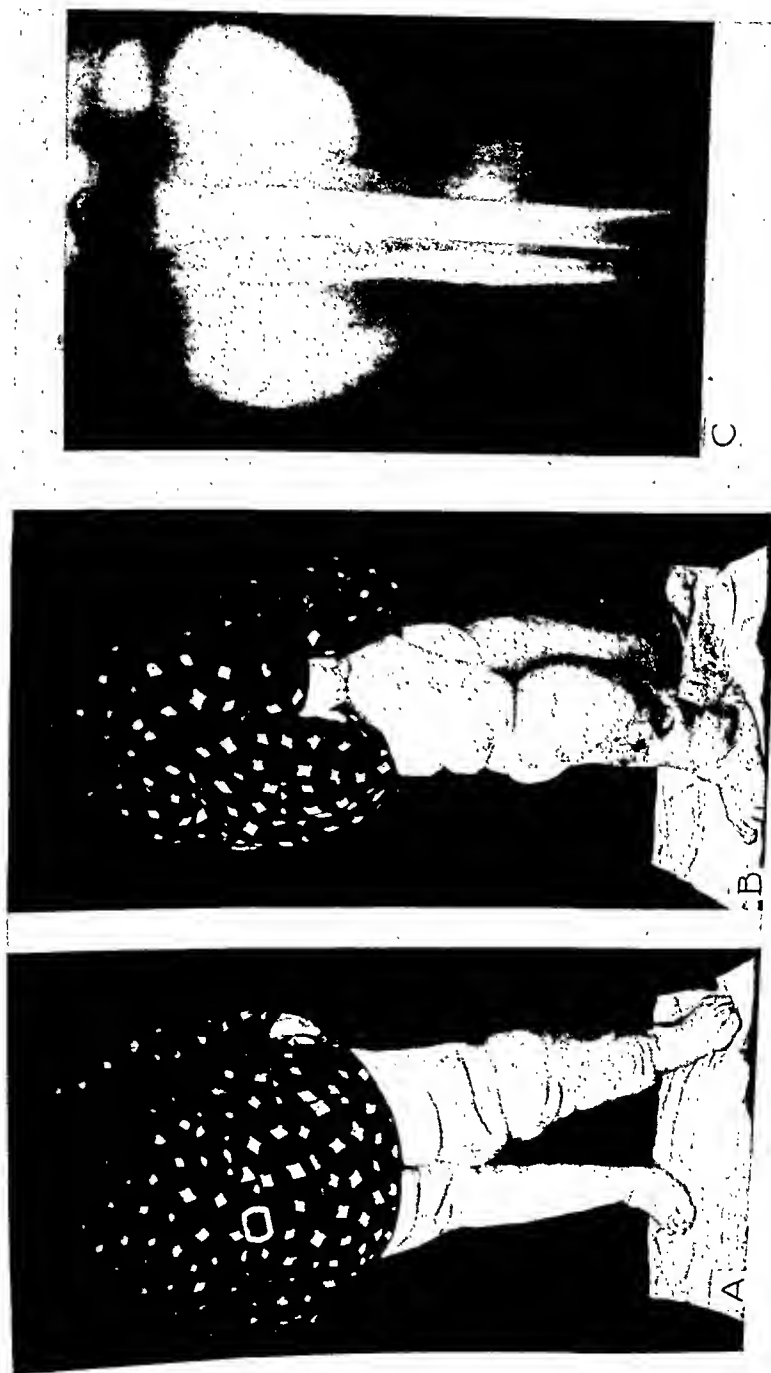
Photographs and x-ray of elephantiasis.
